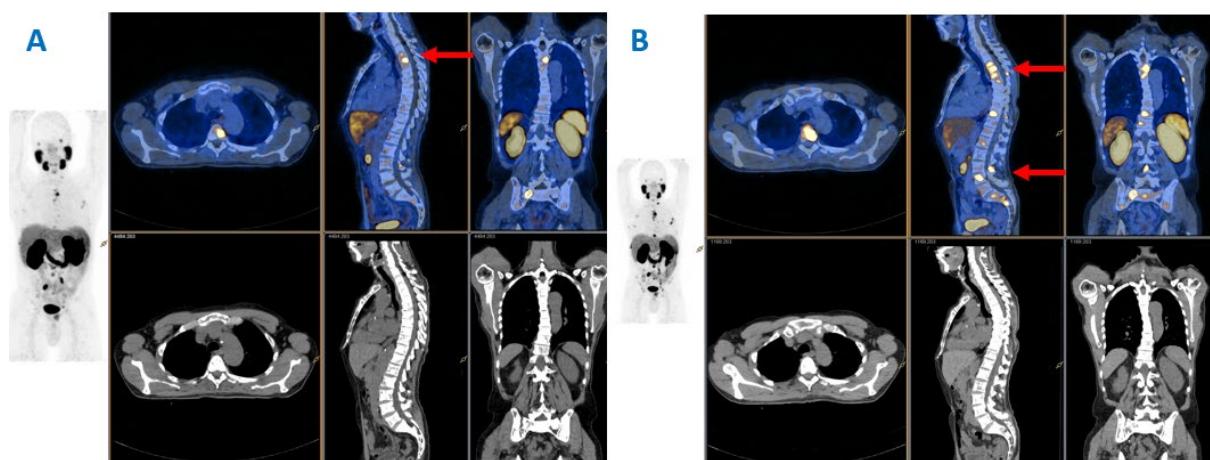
All men with mCRPC experienced an increase in PSMA SUV max and SUV mean in response to ASI. This man (patient B: Figure 2) had an increase in SUV max from 20 at baseline (A) to 30 at day 9 (B) and an increase in the number of metastatic lesions visible on PSMA PET, despite a drop in PSA.
